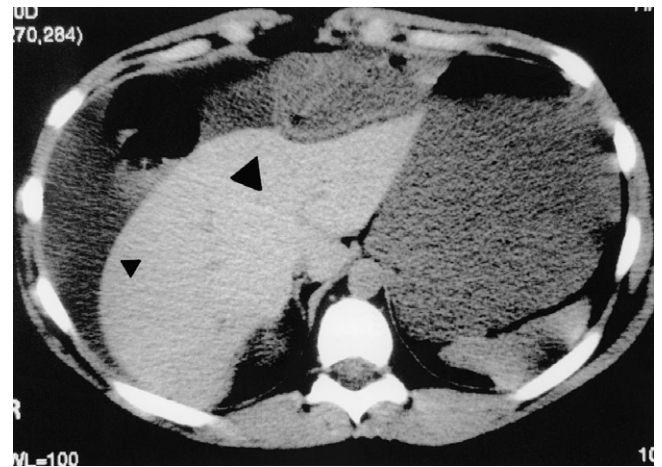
Preoperative contrast-enhanced computed tomography scan of a patient with an internal hernia around the falciform ligament. The patient had feculent emesis and no past surgical history. The *large arrowhead* demonstrates small bowel loops around the falciform ligament, above the liver edge. The right colon is also noted to be above the liver in the right upper quadrant. The *small arrowhead* demonstrates the presence of ascites. The patient was found to have gangrenous small bowel loops present. The falciform ligament was divided, the gangrenous bowel resected, and primary anastomosis performed.
